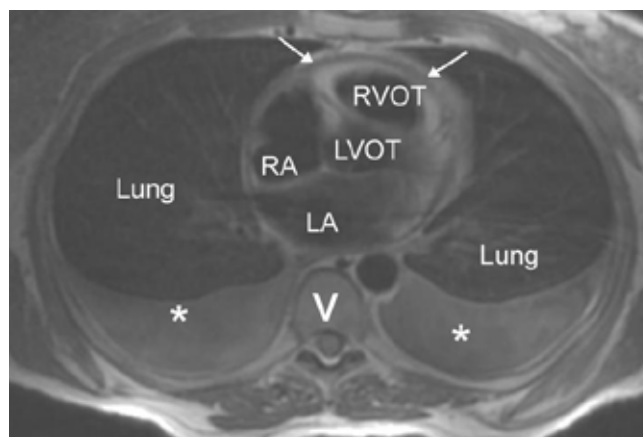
Axial MRI at the level of the right ventricular outflow tract demonstrating large bilateral pleural effusions (\*) and thickened pericardium (arrows).
